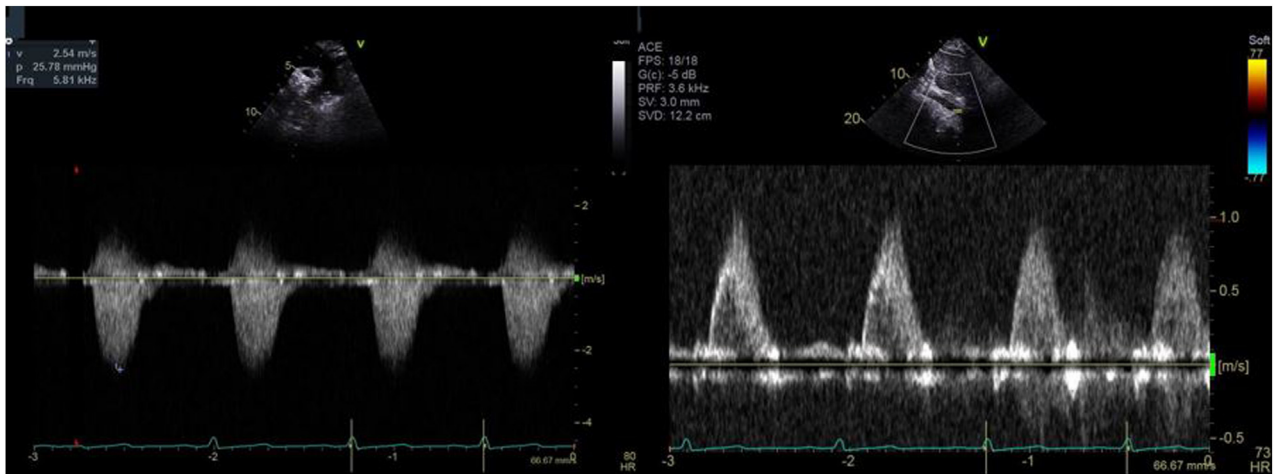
Two-dimensional TTE, aortic arch continuous-wave Doppler, demonstrates peak aortic arch Doppler velocity of 2.5 m/sec (*left*). Two-dimensional TTE, abdominal aortic pulsed-wave Doppler, demonstrates normal pulsatile flow with absence of forward flow in diastole after intervention (*right*).
